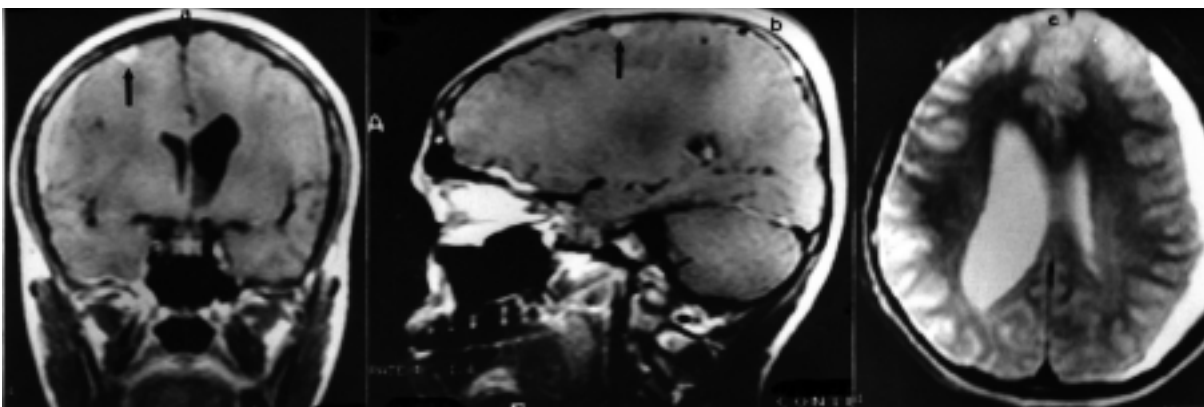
Gadolinium enhanced MRI scans showing enhancing granuloma in the right parietal cerebral convexity in the coronal (a) and sagittal (b) scans (arrow). (c) Hyperintense subdural collection over the right cerebral hemisphere (T2WI).
